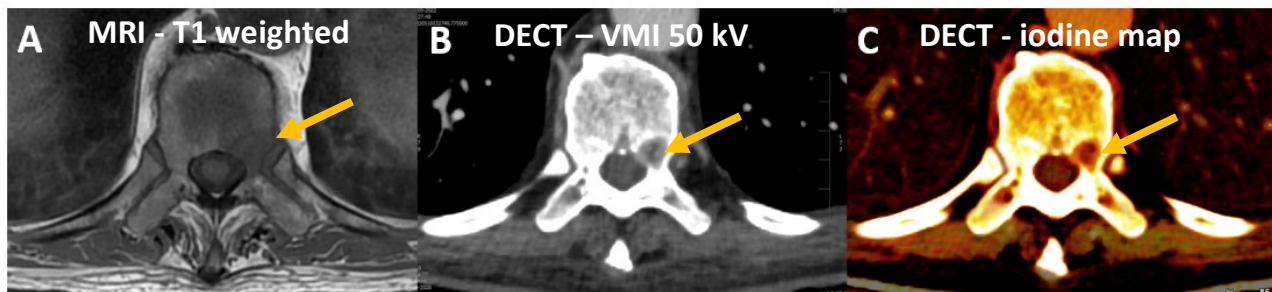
Axial images of a bone metastasis (orange arrow) with discrete epidural growth in a vertebral column. A) T1 weighted MRI, B) contrast enhanced DECT (VMI 50 kV) and C) iodine map reconstruction from DECT. *Courtesy of Erik Brandt (MD), Copenhagen University Hospital Herlev and Gentofte.*
